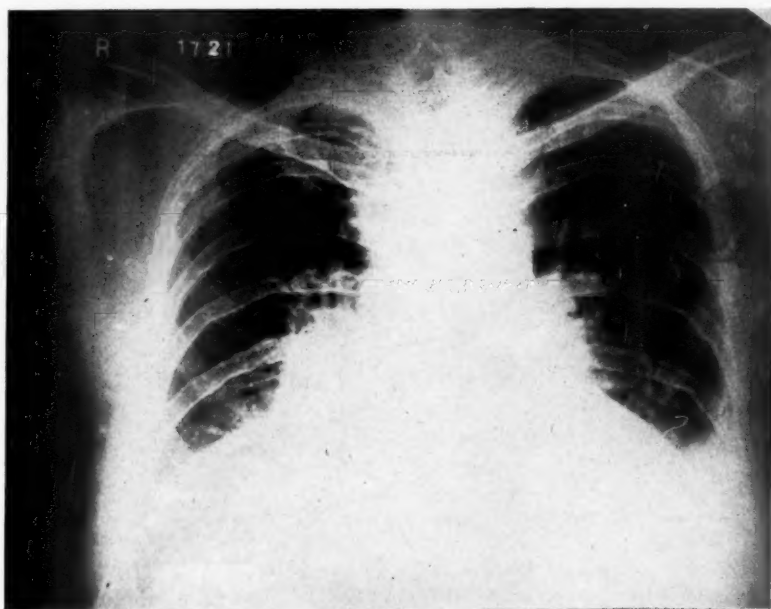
Roentgenogram showing the notchings of the inferior border of the ribs. Note widening of the aortic arch.
